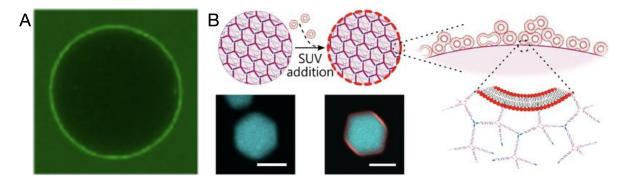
Interfacial engineering of NAJ droplets. (A) dsDNA adhered to an NAJ droplet interface, but excluded from the interior. Droplet is of order 20 μ m. Reprinted with permission from [53]. Copyright 2019 American Chemical Society. (B) SUVs adhered to cholesterol-modified NAJ assemblies, forming a shell around them. Scale bars 10 μ m. Reprinted with permission from [86], excerpted from a larger figure.
